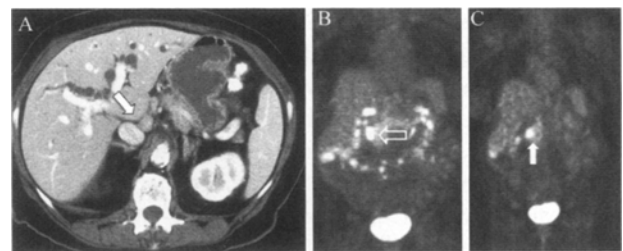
A 67-year-old woman with new-onset abdominal pain and jaundice. (A) Contrast-enhanced abdominal computed tomography demonstrated a pancreatic head mass (not shown) and peripancreatic lymphadenopathy (arrow). (B) Coronal 18-fluorodeoxyglucose positron emission tomography images demonstrate hypermetabolism in the pancreatic head (open arrow) and normal uptake within the gastrointestinal tract. (C) There is persistent enhancement in the region of the pancreatic head (arrow), but this area could not be delineated to discern nodal involvement. The periduodenal node contained metastatic moderately differentiated pancreatic carcinoma.
